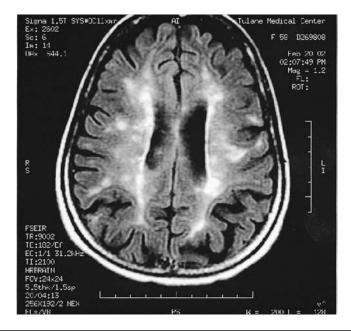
Multiple sclerosis. MRI shows periventricular hyperintense (white) lesions consistent with demyelination.
